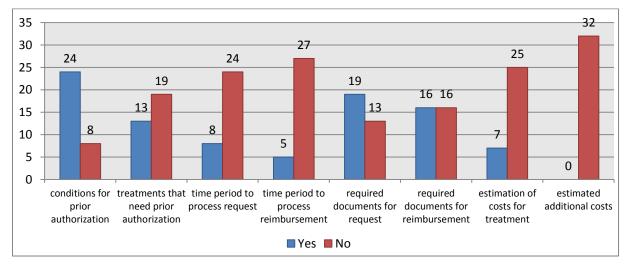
FINANCIAL ASPECTS
